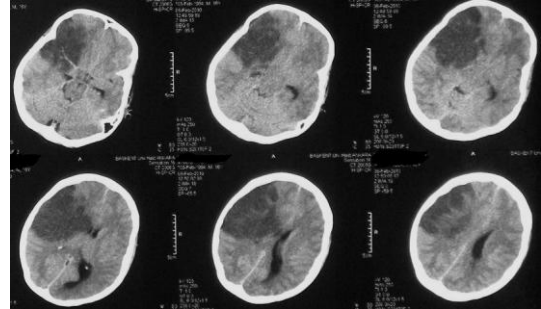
Axial CT shows a large low-density infarction in the region supplied by the right MCA, midline shift from right to left, and closing of the right lateral ventricle due to increased intracranial pressure.
